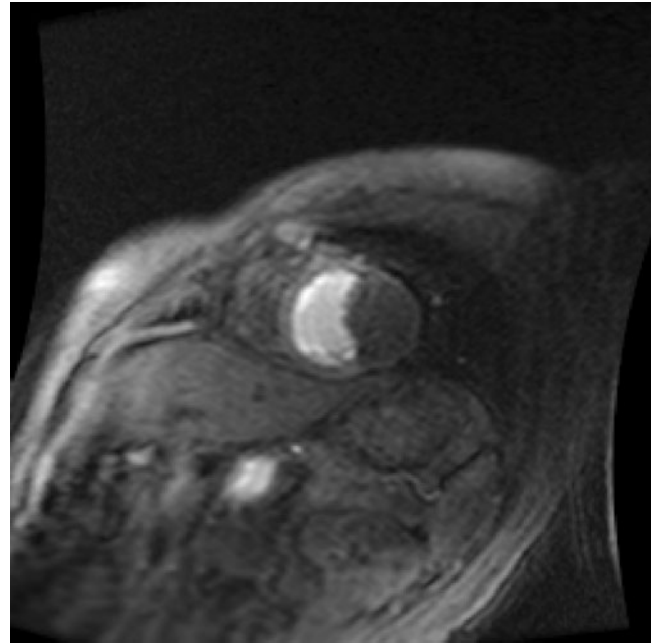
MRI of left ventricular fibroma.
